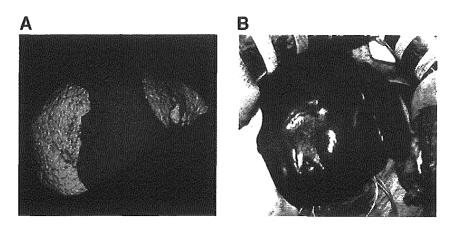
3D-CT image of the congestion area and an intraoperative finding. (A) The construction of the 3-dimensional image shows the drainage area of the MHV tributaries (V5, V8; indicated by red). (B) Discoloration of the donor liver surface after clamping of the right hepatic artery and MHV tributaries, which completely matched the predicted area by 3D-CT (A,B: same donor).
